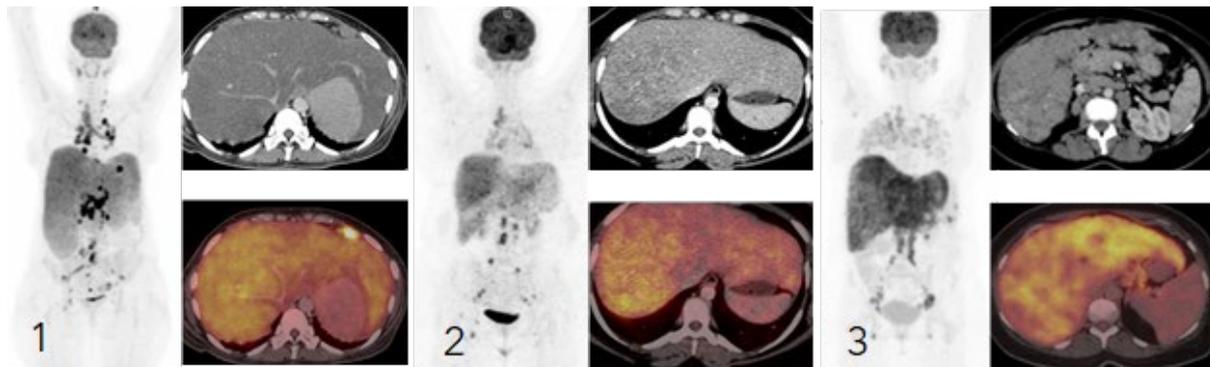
MIP image shows FDG uptake in liver lesions, mediastinal and abdominal lymph nodes and cross-sectional images showing diffuse hepatomegaly with low attenuation and increased FDG uptake.
